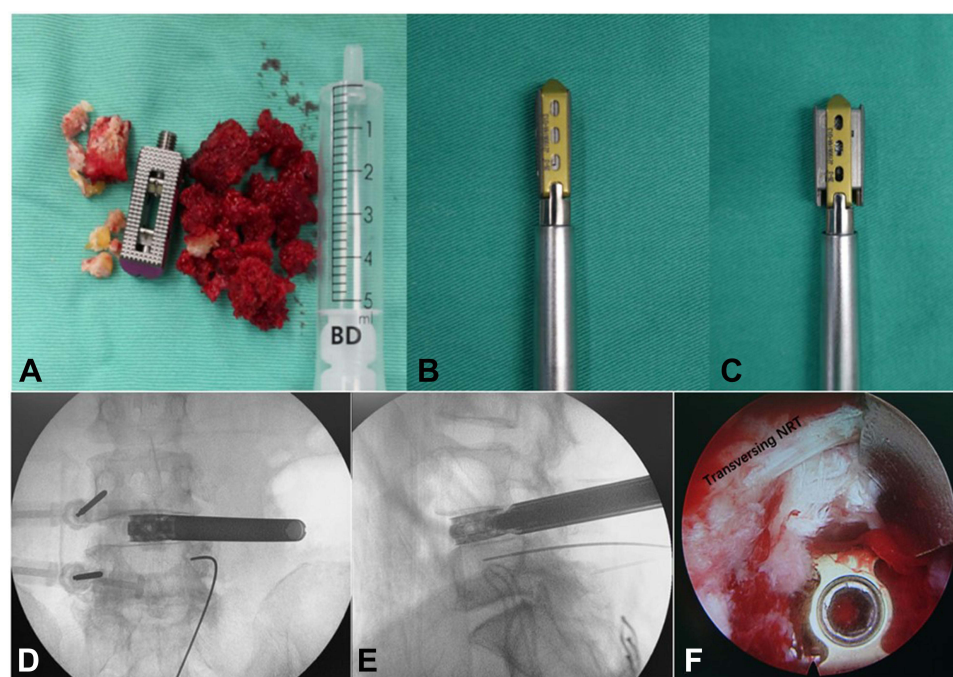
Intervertebral bone graft and interbody fusion device implantation. (A–C) Expandable cage, the autogenous bone, and allogenic bone are prepared for implantation. (D and E) The height-adjustable interbody cage is positioned at the center of the interbody space in the anteroposterior radiograph, and the leading edge reaches the position of the iliac crest. (F) The expandable cage is confirmed in a satisfactory position under endoscopy. Nerves are not compressed by bone graft particles.
